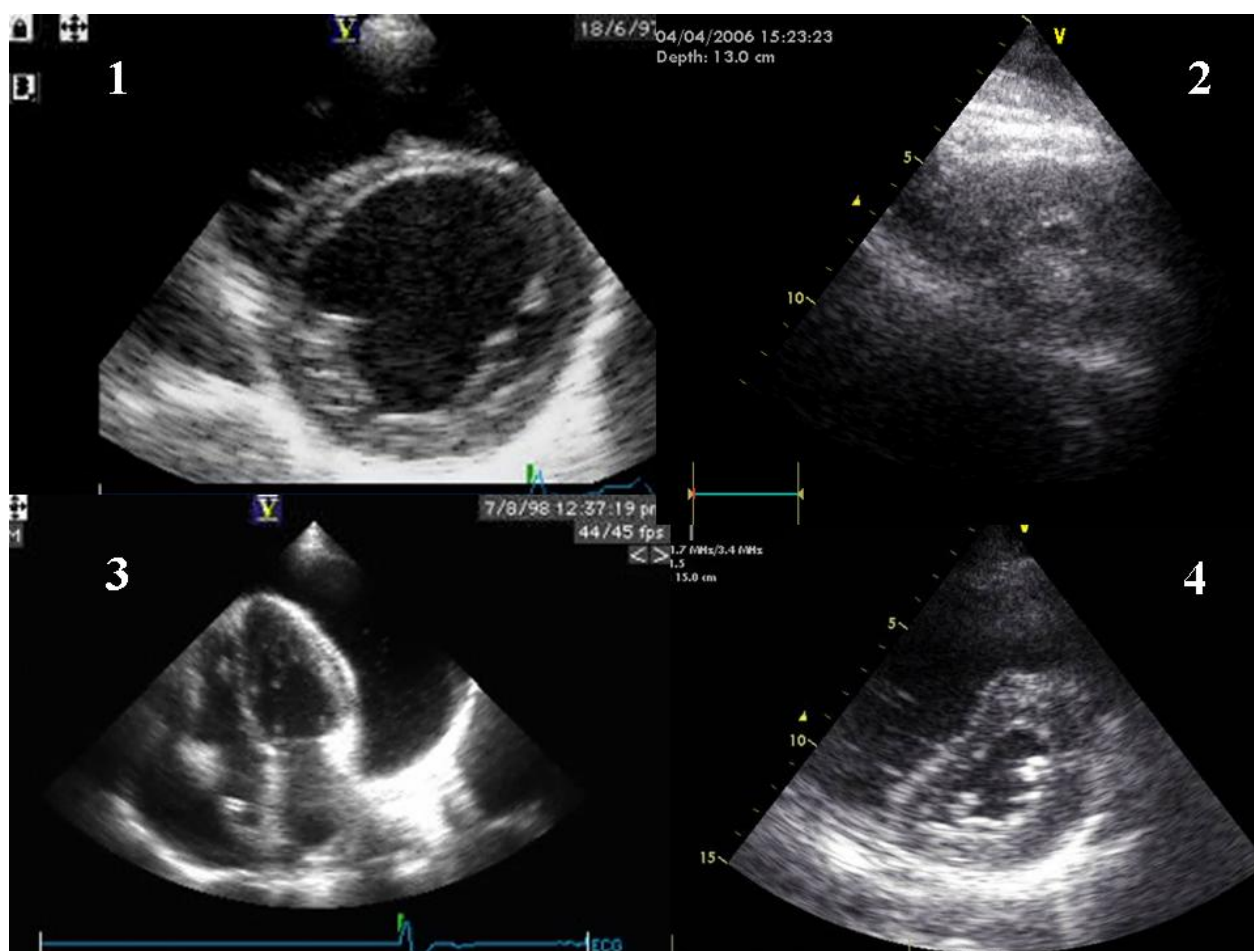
showing the four important causes of shock. 1) dilated and dysfunctional left ventricle, 2) severe left ventricular hypovolemia (poor but sufficiently image quality in an emergency case), 3) pericardial effusion and 4) right ventricle pressure overload with “D”-shaped left ventricle (pulmonary embolus). These cases are extremely difficult to differentiate *clinically* but very easy to recognise by means of echocardiography.
